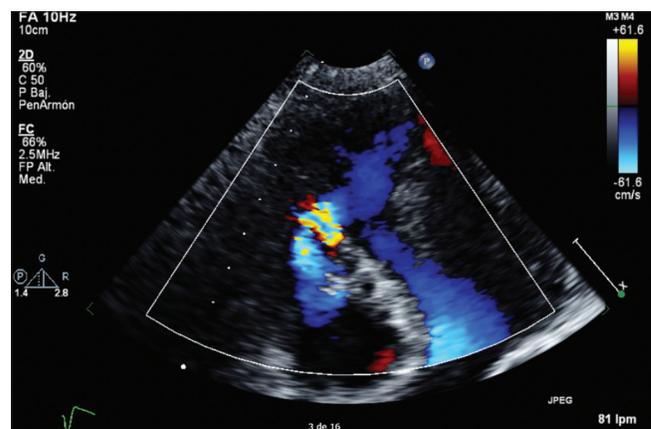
Transthoracic echocardiogram showing an 8-mm apical ventricular septal defect
